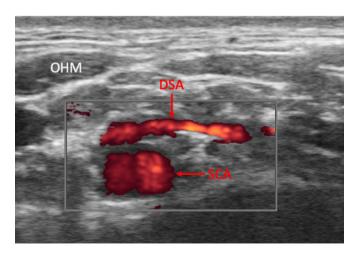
Ultrasound image of the supraclavicular region of the brachial plexus. The large dorsal scapular artery (DSA) is cleary visible in the color Doppler mode above the subclavian artery (SCA). OHM, omohyoid muscle; left side, medial.
